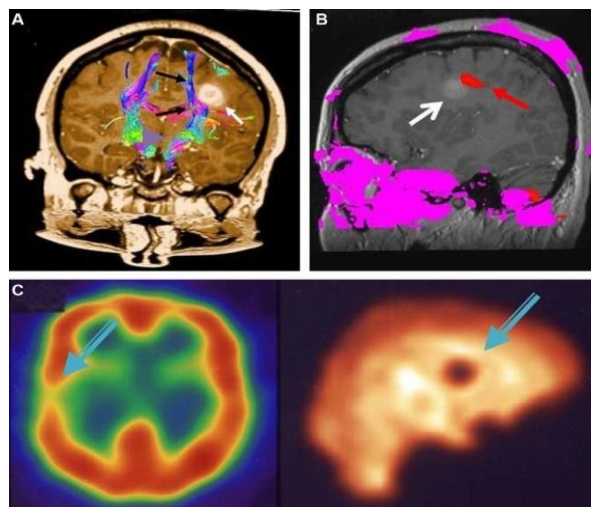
DTI-derived tractography (1.5-T MRI scanner; diffusion gradients in 30 non-colinear directions [11].
